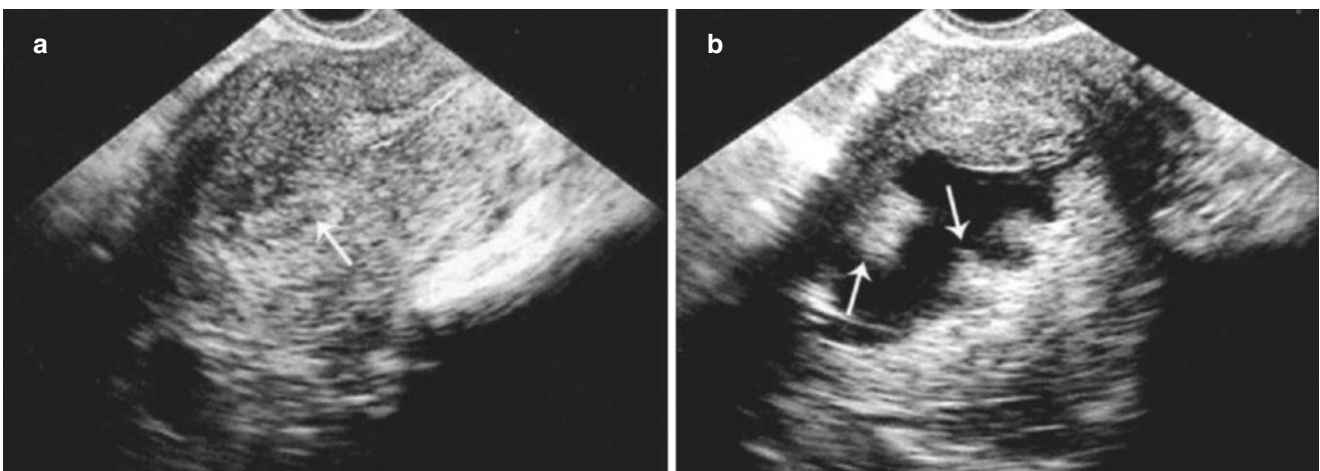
Endometrial polyps (II). A 45-year-old patient with a history of menstrual disorder for 1+ year received an ultrasonic examination. (a) Sagittal view of TVS shows heterogenous thickened endometrium.
